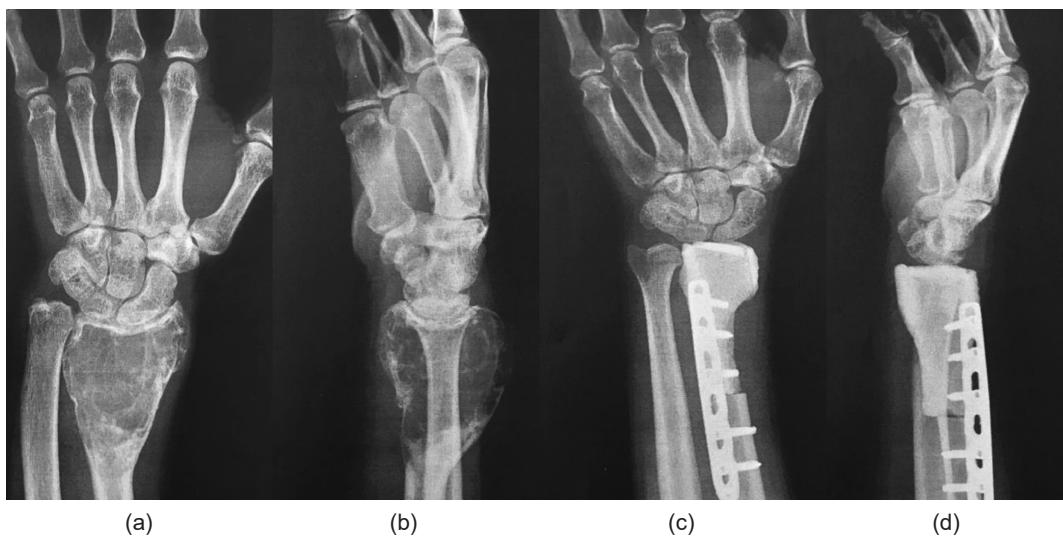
Preoperative and postoperative distal radial ulnar joint bone X-ray.
